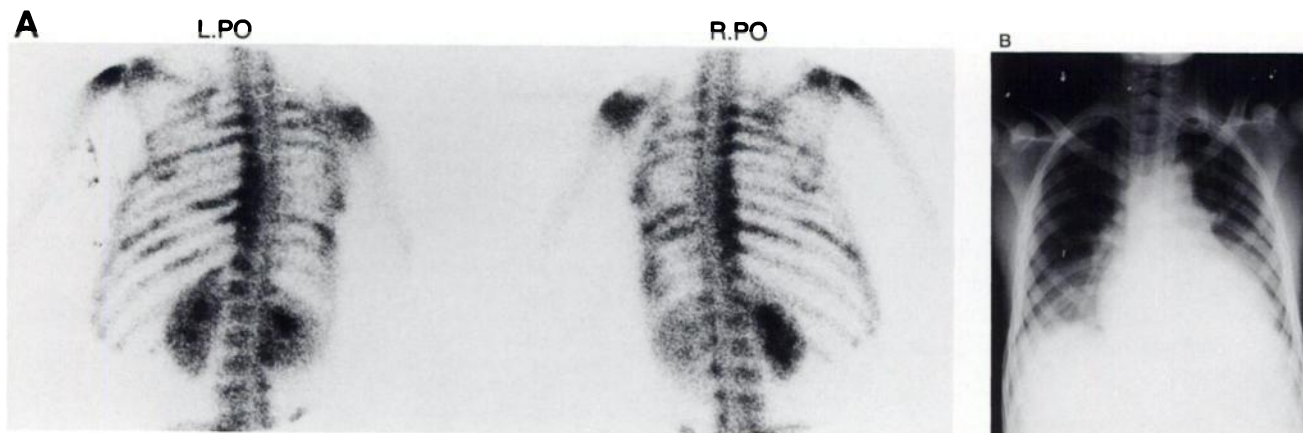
(A) A 14-yr-old male with sickle cell disease (Hgb SS). On the bone scan there are multiple areas of increased and decreased uptake in the ribs and multiple thoracic vertebra with increased uptake. (B) Chest radiograph demonstrates bilateral lower lobe infiltrates.
